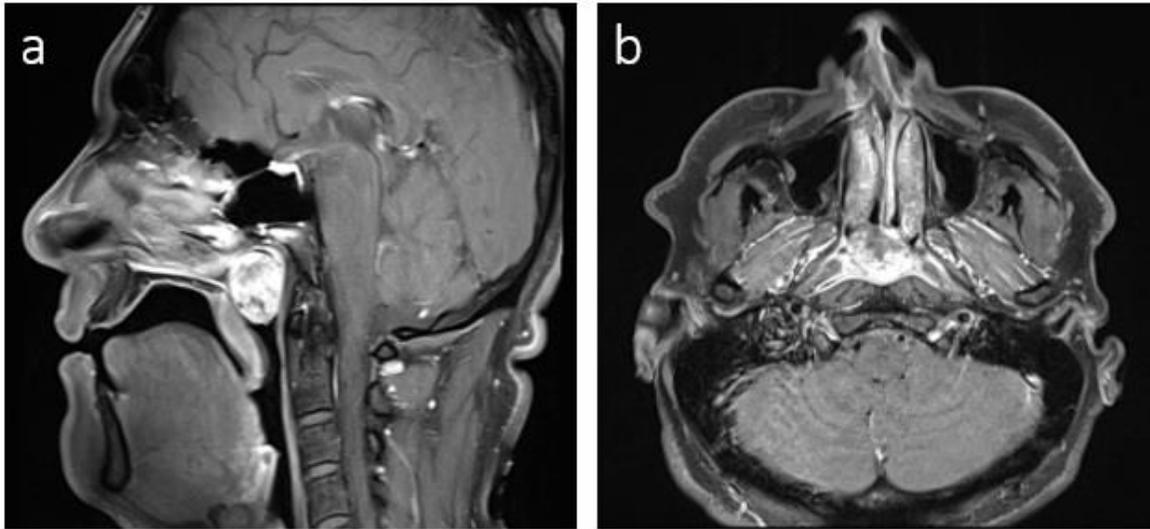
Preoperative MRI shows a 26x23x26 mm mass with heterogeneous contrast and minimal pathological diffusion restriction.
